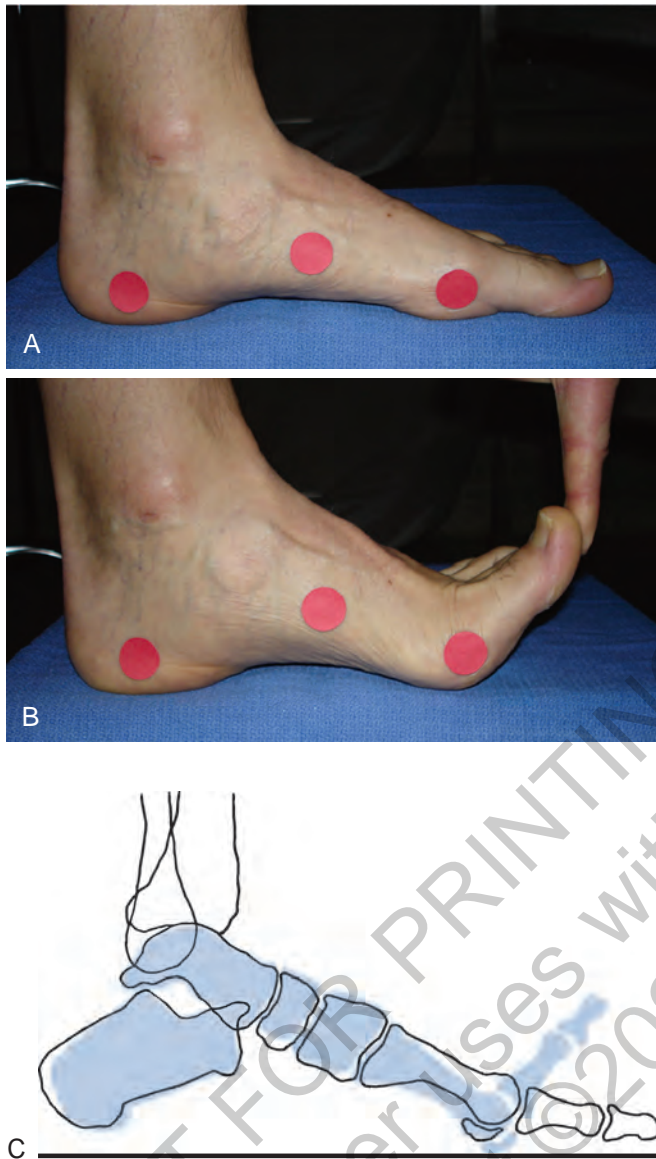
Dynamic function of plantar aponeurosis. A, Foot at rest. B, Dorsiflexion of metatarsophalangeal joints, which activates windlass mechanisms, brings about elevation of longitudinal arch, plantar flexion of metatarsal heads, and inversion of heel. C, Superimposed tracing of lateral radiographs of the foot at rest (*outline*) and with first ray dorsiflexion (*gray figure*). Notice that dorsiflexion of the first toe tightens the plantar aponeurosis, which results in depression of the metatarsal heads, elevation and shortening of the longitudinal arch, inversion of the calcaneus, and elevation of the calcaneal pitch. (C, from Haskell A: Foot and ankle biomechanics. In Miller MD, Thompson SR, editors: *DeLee, Drez, and Miller's orthopaedic sports medicine*, Philadelphia, 2020, Elsevier.)
